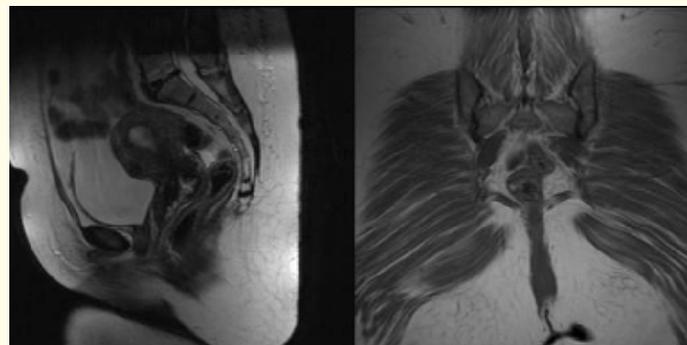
MR images (A) is sagittal section, which shows an open anal canal with torn IAS in a patient who suffers FI. Image (B) is a coronal section, which shows an open anal canal with torn IAS, with some stool leaking.
